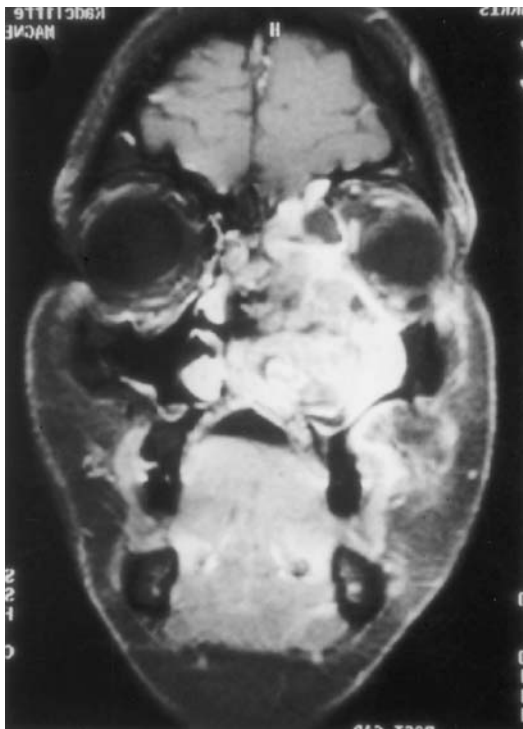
Coronal MRI of patient with carcinoma of paranasal sinuses with involvement of the anterior cranial fossa.
